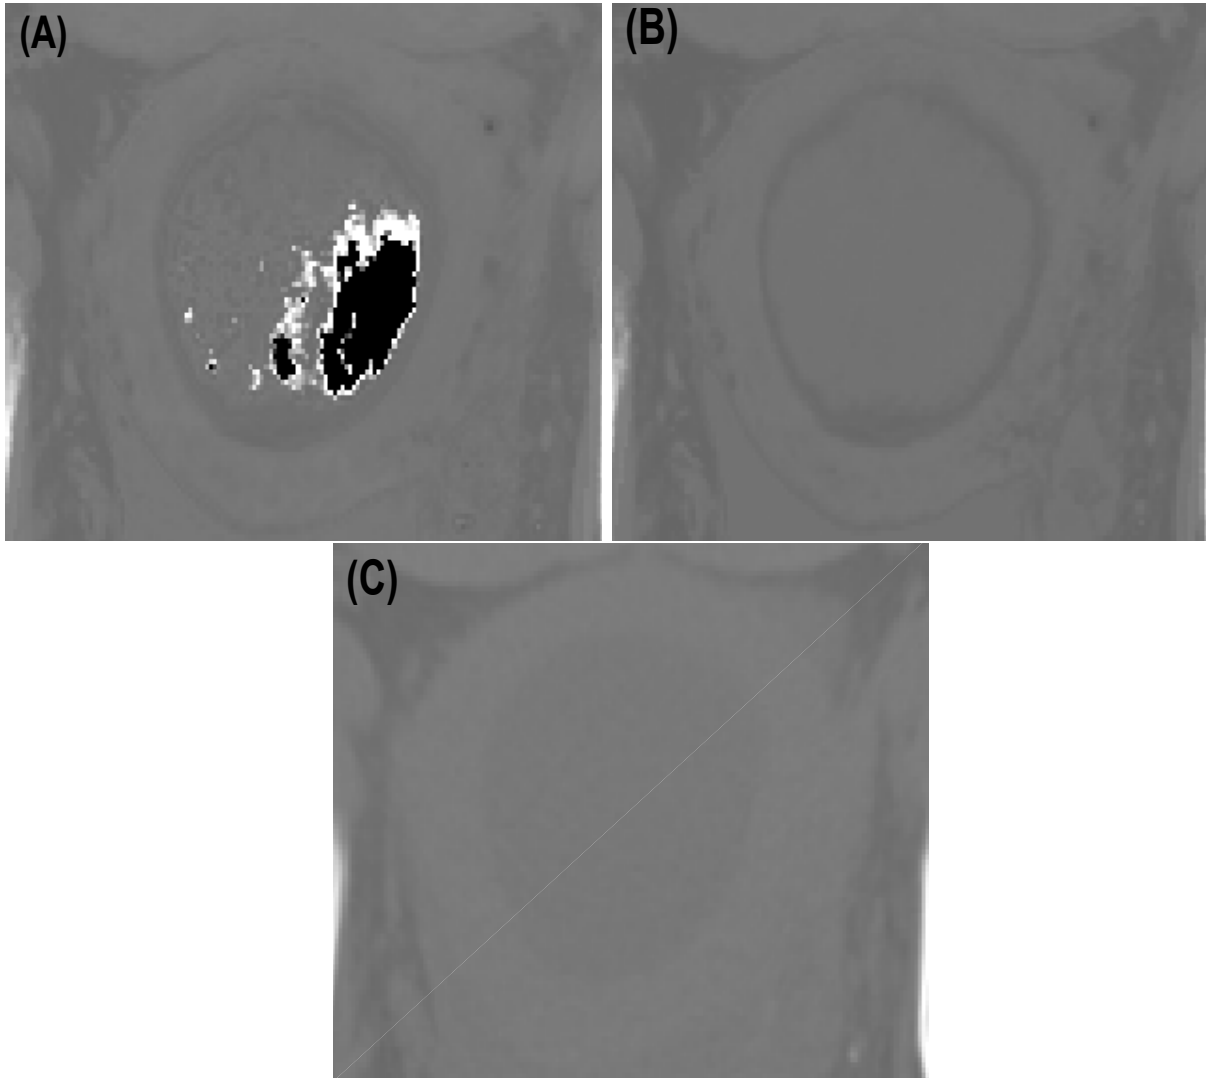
Effect of bin filling on pCT image: (A) without bin filling. (B) with bin filling. (C) Reference-CT.
